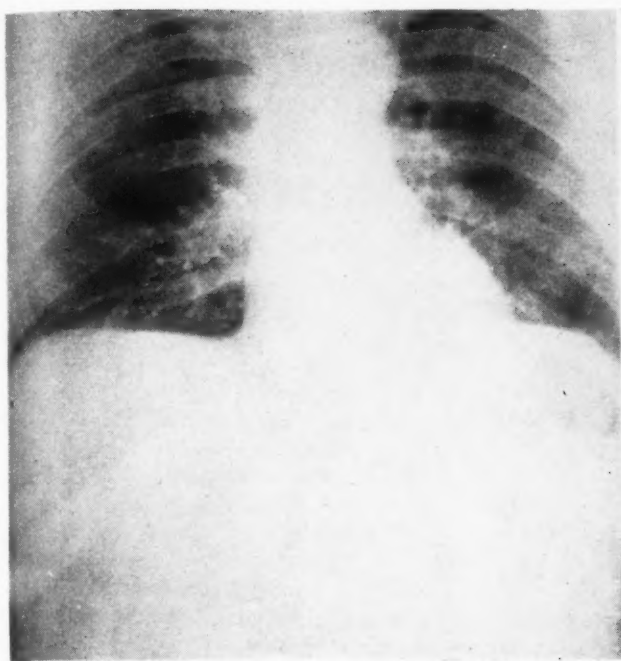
Roentgenogram taken five hours after perforation on December 14, 1945, shows no free air under the diaphragm.
